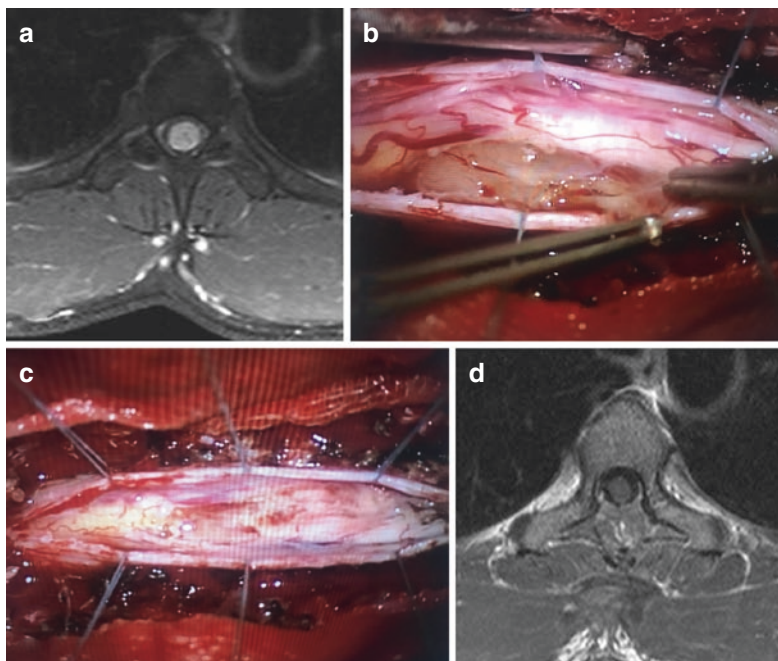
(a) Axial T1-weighted MRI image with contrast media showing a T2–3 schwannoma in a 40-year-old man with weakness of the lower extremities due to the extreme compression of the spinal cord. (b) Intraoperative exposition of the lesion via T2–3 laminotomy. (c) Surgical site after removal of the lesion. (d) Postoperative axial T1-weighted post-contrast MRI image with contrast media demonstrating the total removal of the lesion
